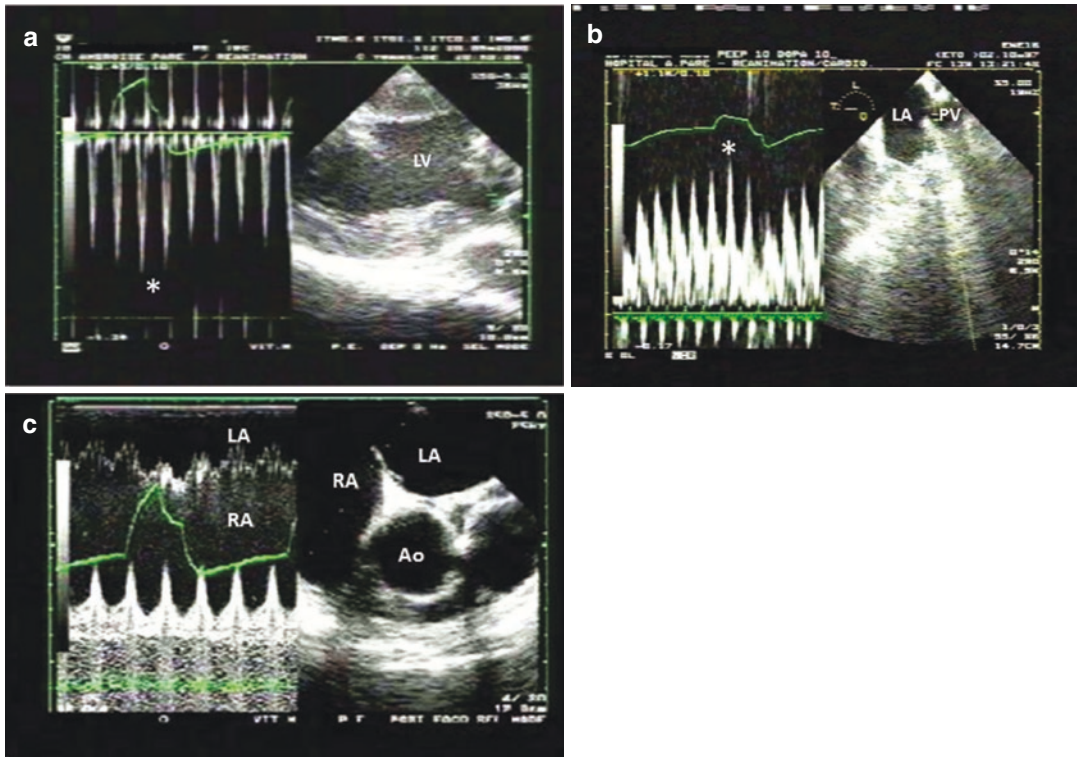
TEE in a ventilated patient. Note that the airway pressure trace appears in green on the screen. Panel a: pulsed wave Doppler in the left ventricular outflow tract in (transgastric view) demonstrated an increase in LV ejection flow during tidal ventilation (asterisk). Panel b: the pulsed wave Doppler in the left and upper pulmonary vein
